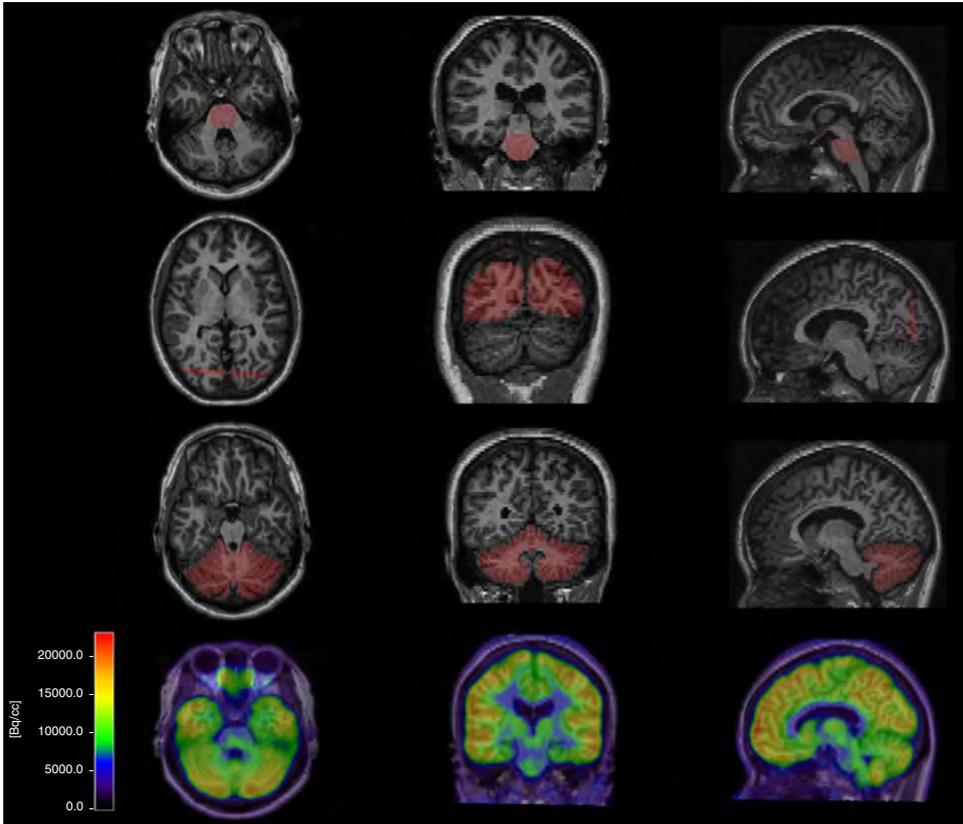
Co-registered T1-MR and FDG PET of a control.
